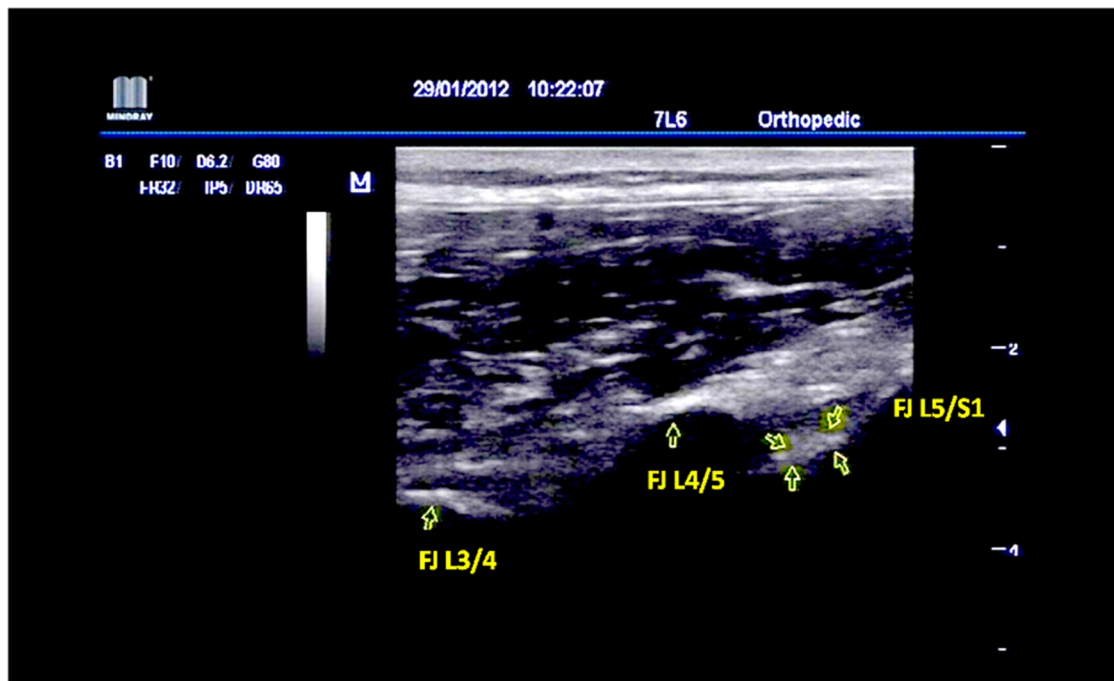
In-plane ultrasound visualisation of lumbar facet joint. Linear probe, 5 MHz, focus depth set to 28 mm. FJ – corresponding facet joints. A position of facet joints and appropriate segment was marked on the skin, maintaining the same position for treatment [image from author's archive].
